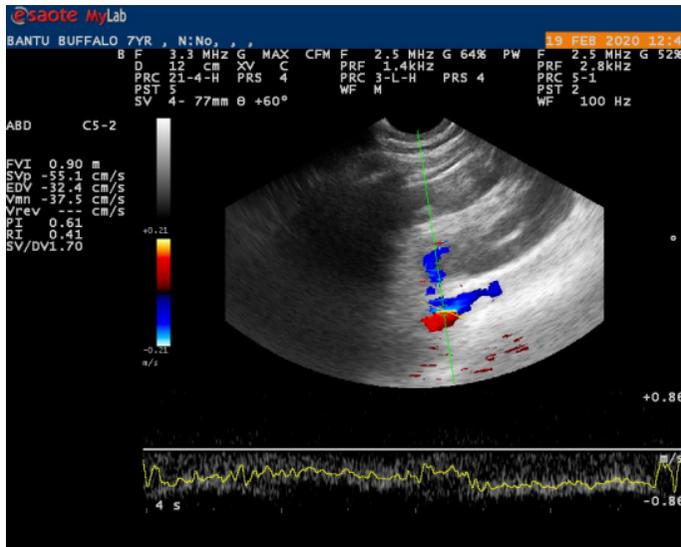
Spectral display showing doppler scan of CVC.
